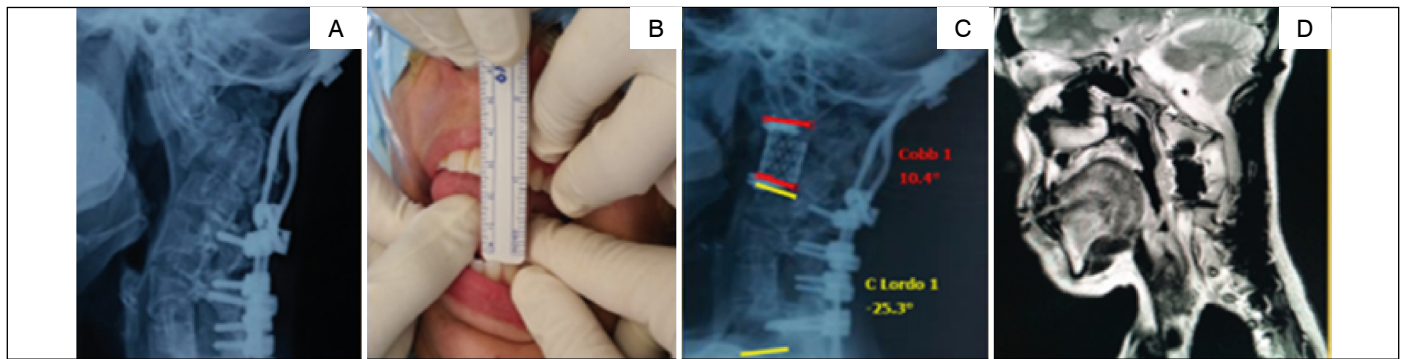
A – Occipitocervical fixation. B – Mouth opening < 3cm. C – Postoperative of anterior approach. D – MRI with medullary decompression.
